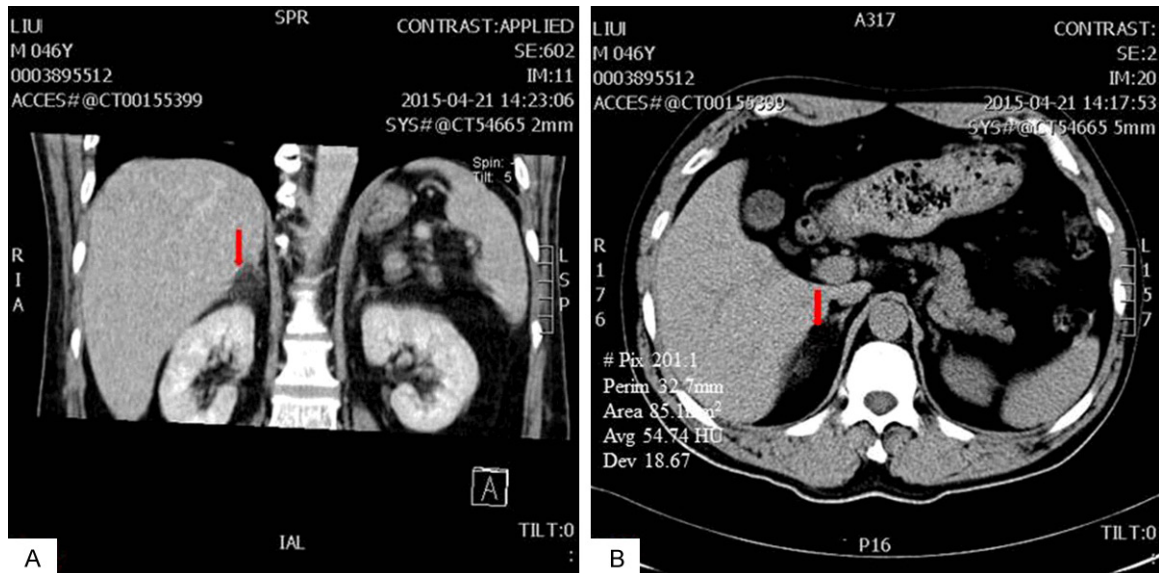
Contrast enhanced computed tomography in vertical section (A) and transverse section (B), showing a 1.7 cm in diameter well-defined heterogeneous enhancing predominantly fat attenuating lesion involving the lateral branch of right adrenal gland (red arrow).
